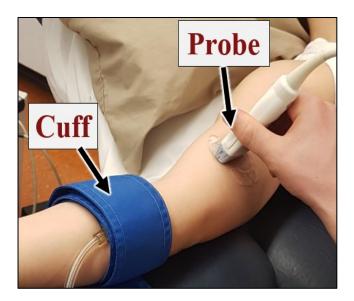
Ultrasound probe and distal pressure cuff set-up for the brachial flowmediated dilation (FMD) assessment of endothelial-dependent vasodilation. The probe was connected to a duplex ultrasonography machine and the rapid-inflation pressure cuff secured around the widest circumference of the forearm. After 2 minutes of baseline recordings, the cuff was inflated to suprasystolic levels to induce distal ischemic. After 5 minutes, the cuff pressure was released to elicit a reactive hyperemia (increase in blood flow), the stimulus for the FMD response.
